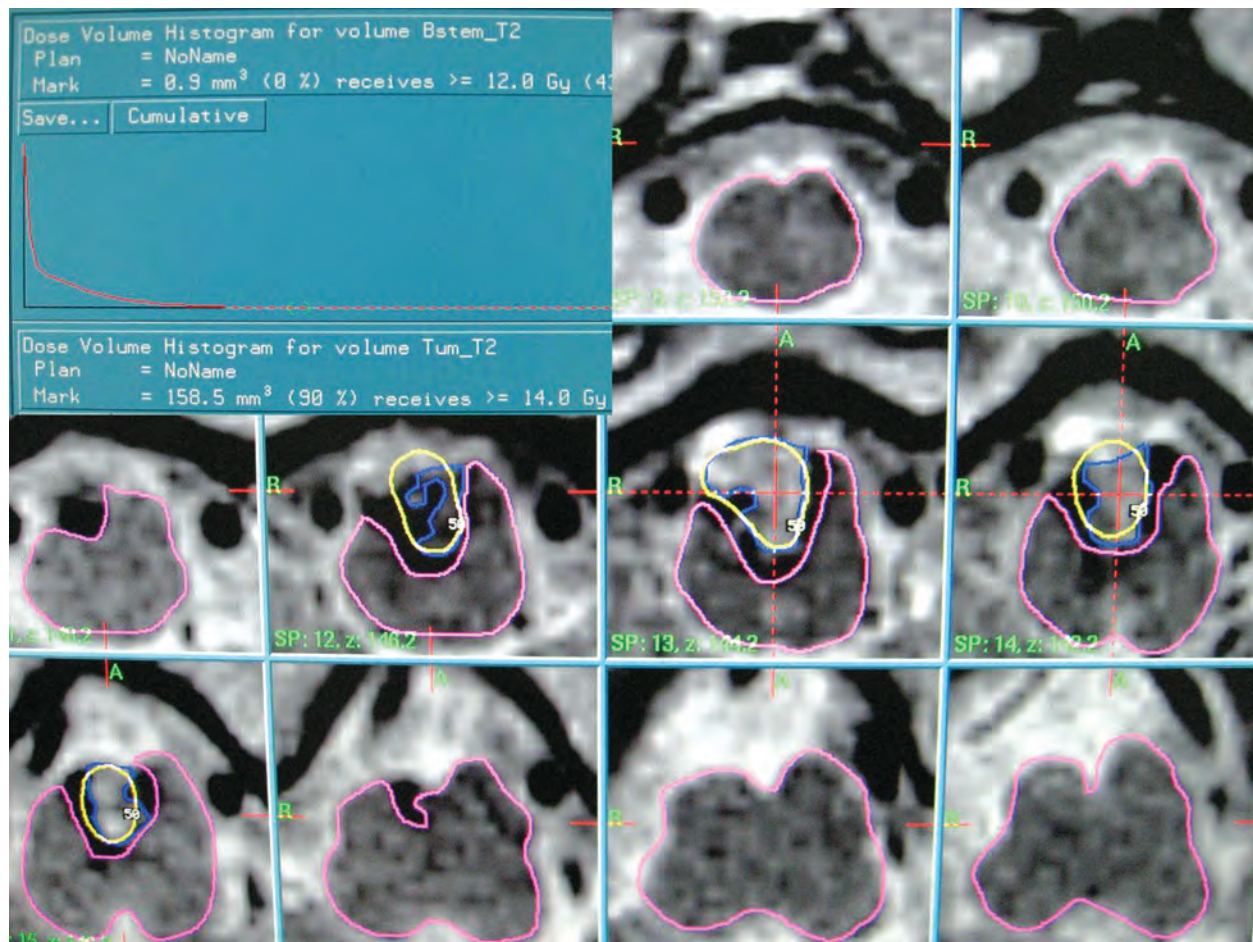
Treatment planning for an intra-medullary cavernoma (T2-weighted MR axial images). Surgery was considered very high risk and consent was taken for GKS, as the patient had two previous bleeds (see text for rationale). The haemosiderin ring was excluded and the brainstem exposure was below 12 Gy (see Dose volume histogram in the inset). The brainstem is segmented in pink, the cavernoma in blue; the yellow line marks the 14 Gy 50% isodose line
